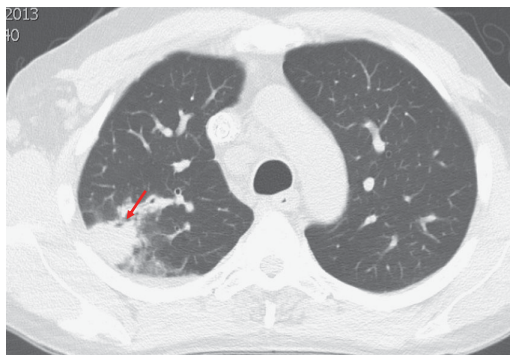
CT chest revealing nodular right upper lobe consolidation.
